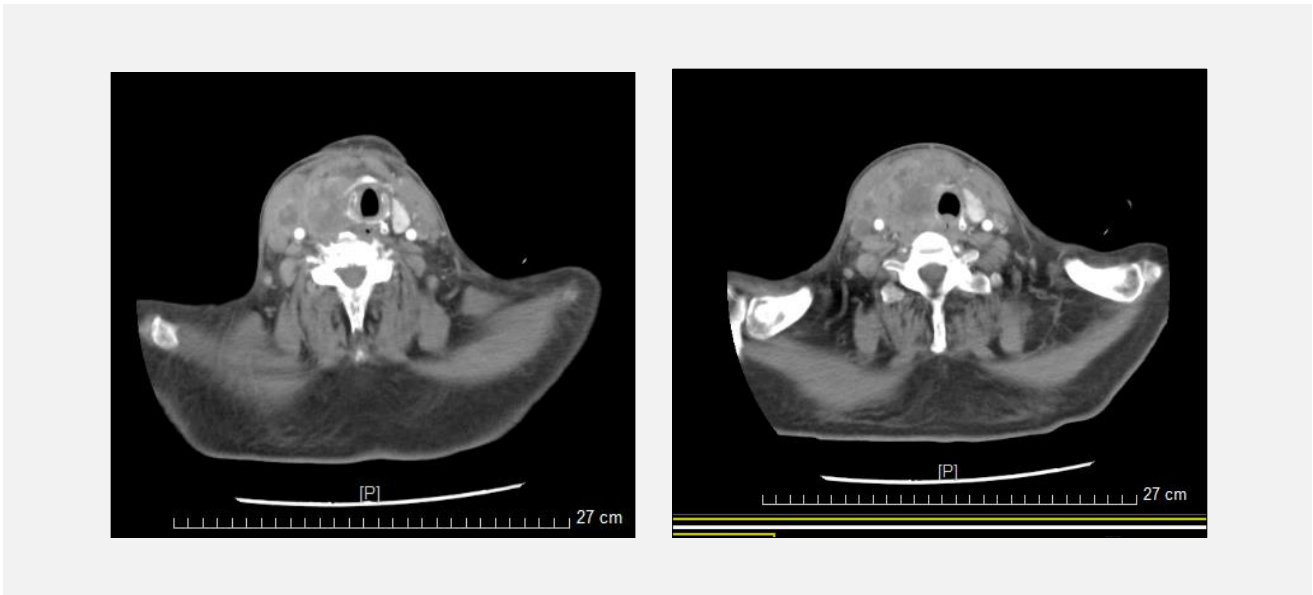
Patient's enhanced chest CT results.
